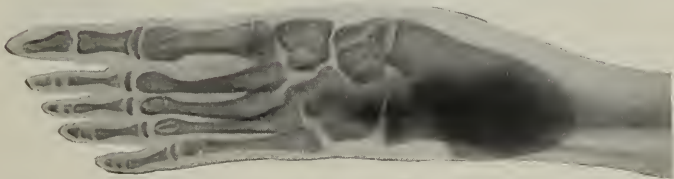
Radiograph of the Left Foot in the same Case (Fig. 159), showing Abduction of the Scaphoid upon the Astragalus.
